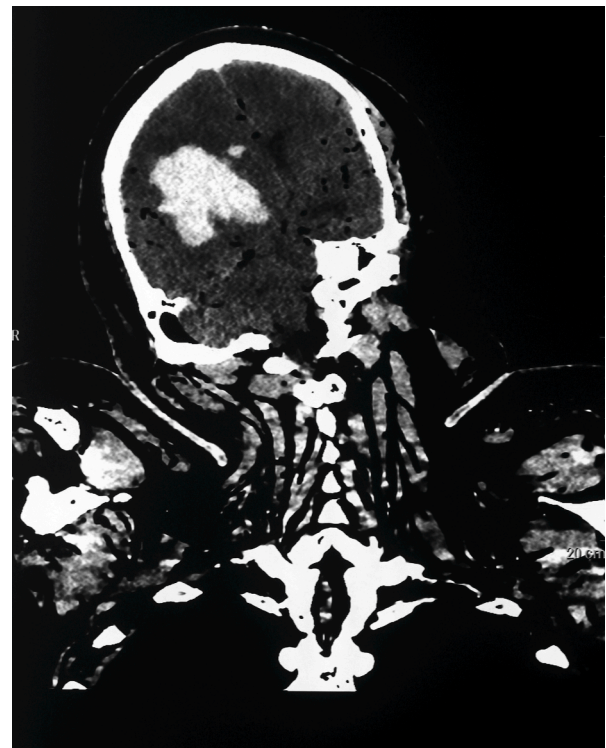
CT Head and neck, Coronal view: Air is seen diffusely in the arteries of the neck, infra and supratentorial brain, IJV, bilateral sigmoid sinuses, basal cisterns, both orbits, and spinal canal.
